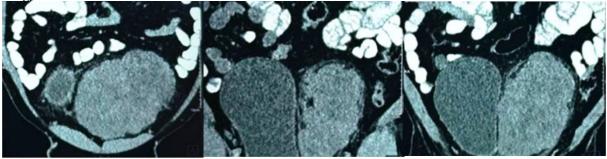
MRI pelvis revealed a large well defined lobulated hetero intense lesion measuring~14.4x8.6x12.4 cm noted in mesentery of lower abdomen infra umbilically with extension into pelvic region
